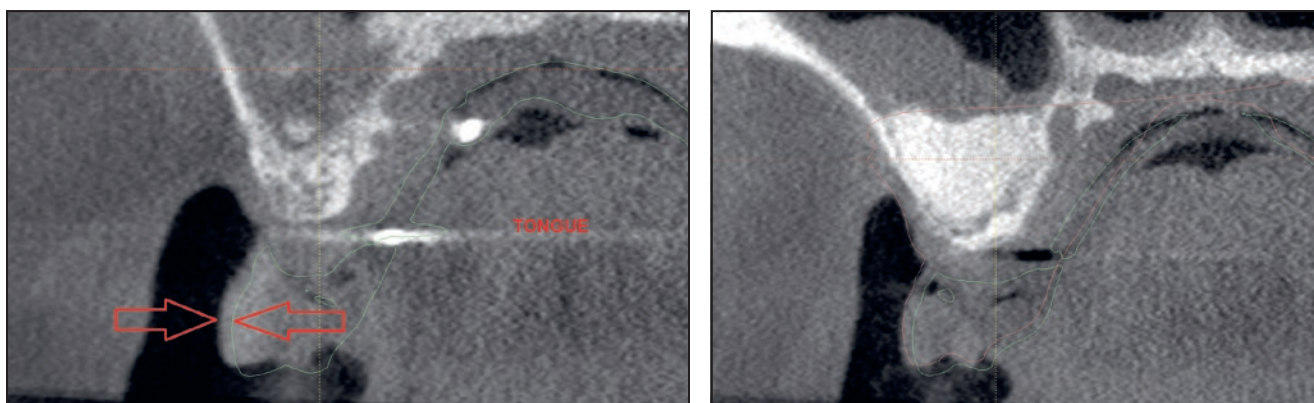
The addition of the full retraction protocol will improve the ability to diagnose possible mismatches of STL files on the DICOM files, including cases in which radiopaque markers are in use. The arrows point to the deviation in position between the gray CT image and the green outline of the STL scan.
